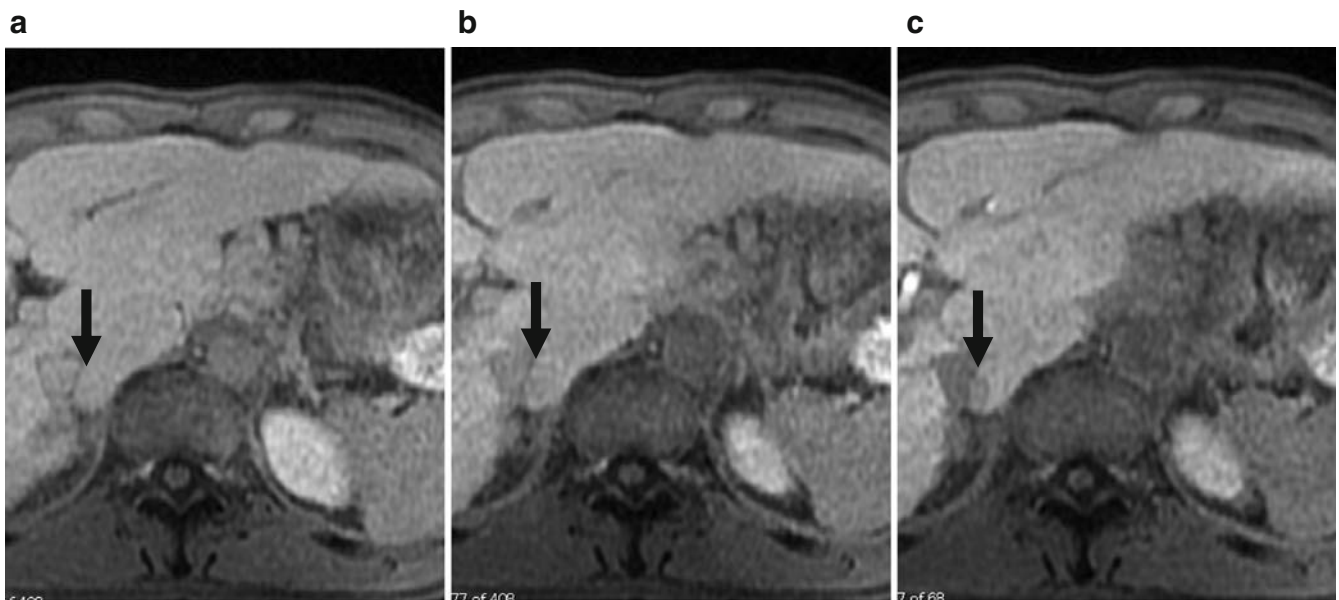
Gd-EOB-enhanced T1-weighted image obtained 5 (a), 10 (b) and 20 min (c) after injection. The visualised liver–spleen contrast was assigned ‘good’ for all images. Q-LSC was 1.38, 1.68 and 1.95 in the images obtained 5, 10 and 20 min after injection, respectively.
